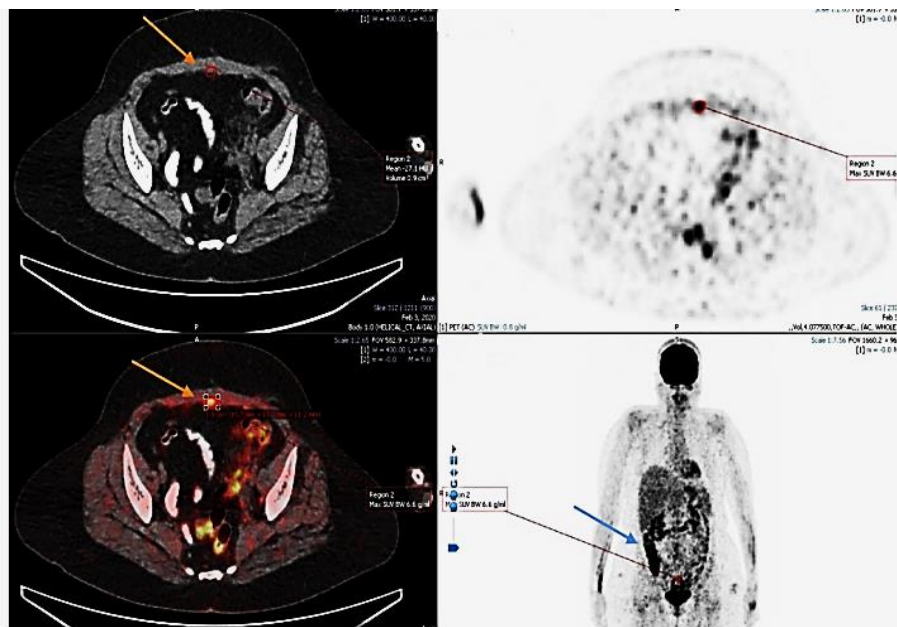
A 50 years old known ovarian CA patient with raised CA-125 levels, PET/CT shows lower abdominal wall nodule representing scar deposit (orange arrow), while blue arrow shows normal bowel uptake.
